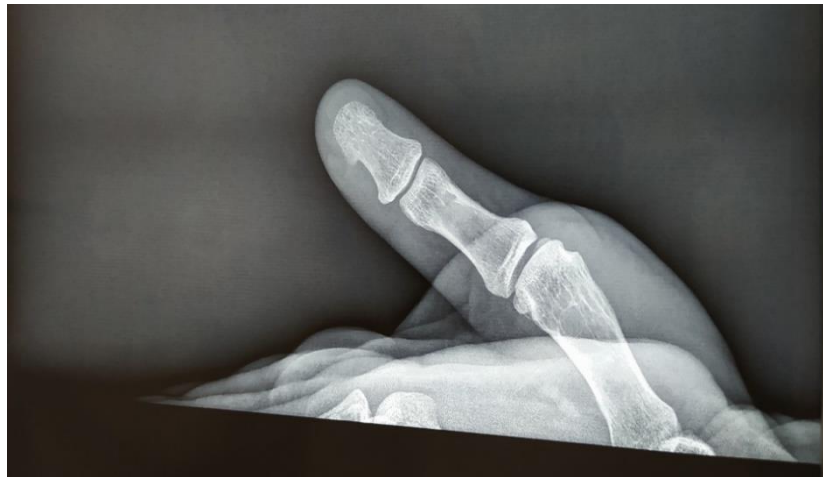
Absence of bone lysis on hand radiography.
